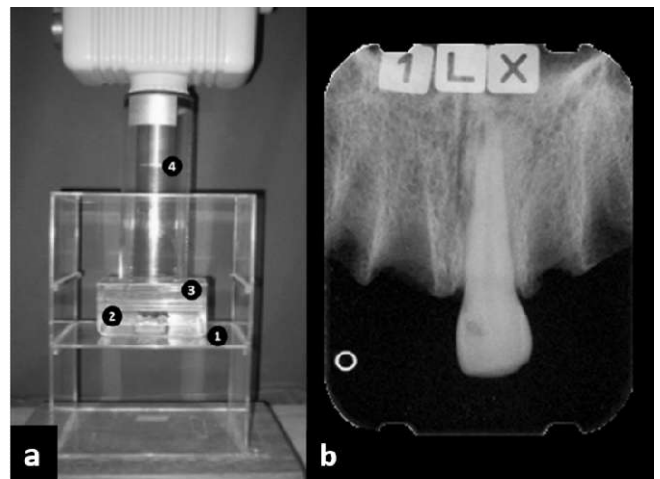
(a) Acrylic device for the standardization of the parallelism technique and (b) radiography obtained with the standardization of the technique. (1) Lower edge of the acrylic box, (2) bone/tooth block, (3) acrylic recipient containing water, (4) acrylic cylinder containing the X-ray tube
